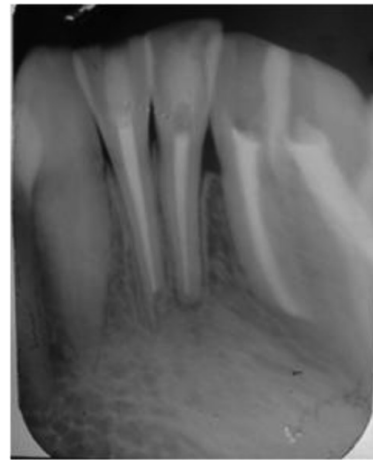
1year Post-operative Radiograph showing complete bone healing.
